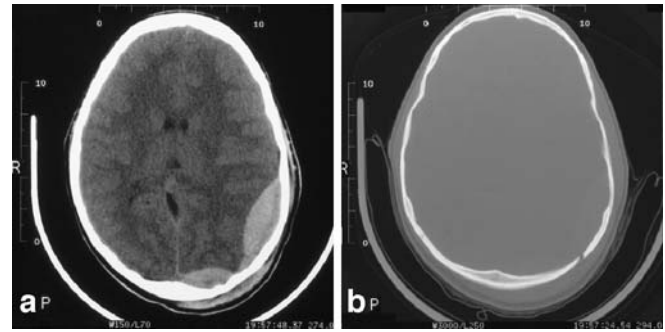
a CT on admission of a 13 1/12-year-old girl with parieto-occipital epidural haematoma with compression of the ipsilateral lateral ventricle and a midline shift of 6 mm and b diastasis of the lambdoid suture (patient number 3)
